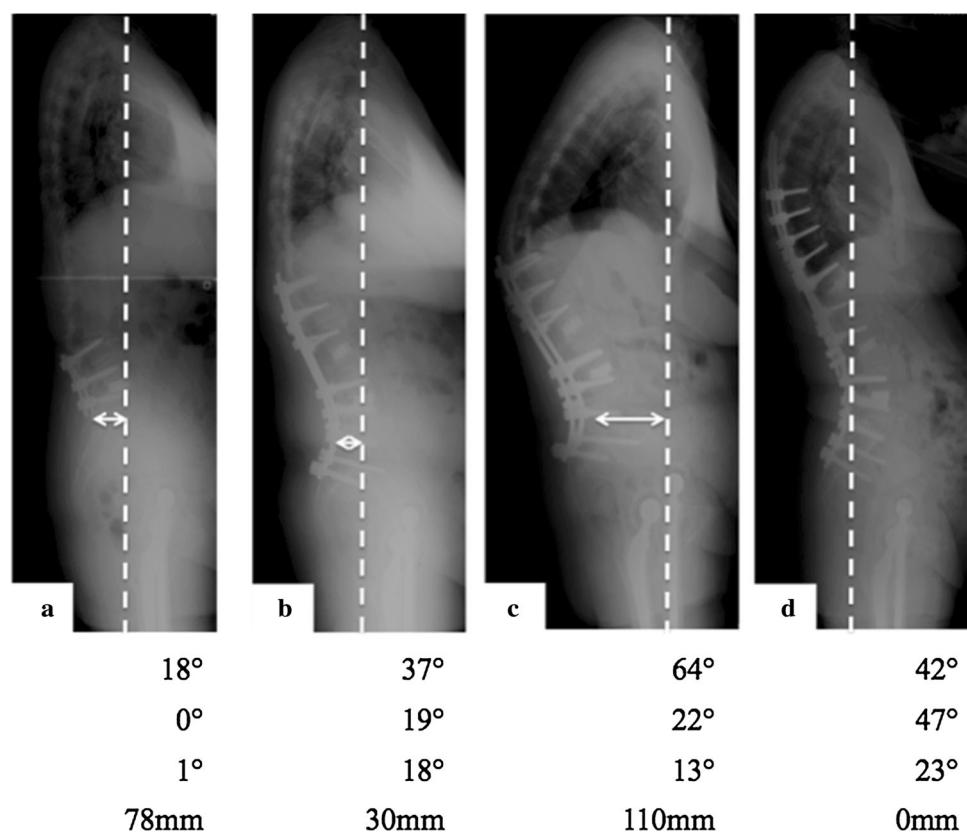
Standing lateral full-length radiographs reveal the change in the spinal sagittal alignment during the series of the spinal surgeries. The sagittal vertical axis (SVA) is defined as the distance between the C7 plumb line (white dotted line the vertical sagittal line that extends from the center of the C7 body) and the postero-superior edge of the sacrum. Thoracic kyphosis (TK) measured from the superior endplate of T5 to the inferior endplate of T12. Lumbar lordosis (LL) measured
